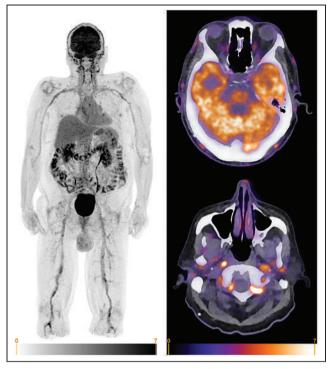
Digital <sup>18</sup>F-FDG PET/CT of 80-y-old male with suspected GCA. Patient's main symptom consisted of both-sided temporal headache, which was accompanied by fatigue. Laboratory investigation showed C-reactive protein of 120 mg/L. (Left) Maximum-intensity-projection <sup>18</sup>F-FDG PET image showing strongly elevated uptake (significantly higher than background) in cranial arteries, most notably in superficial temporal and carotid arteries. Elevated uptake (similar to liver uptake) can be seen in subclavian, axillary, femoral, and popliteal arteries. These findings are highly suggestive of C-GCA and LV-GCA. In addition, moderate uptake can be seen around shoulders and hips, suspected for PMR activity. (Right) Axial <sup>18</sup>F-FDG PET/CT fusion images of head. (Right top) Elevated uptake in frontal and parietal branches of superficial temporal artery, left posterior auricular artery, and occipital arteries. (Right bottom) Significantly increased uptake in internal carotid and vertebral arteries. Elevated uptake can also be seen at junction of external carotid artery and common superficial temporal artery, as well as maxillary arteries and right posterior deep temporal artery.
